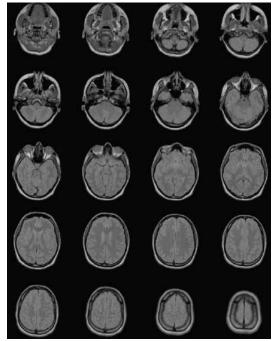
Multiple scans obtained from a CT study.
